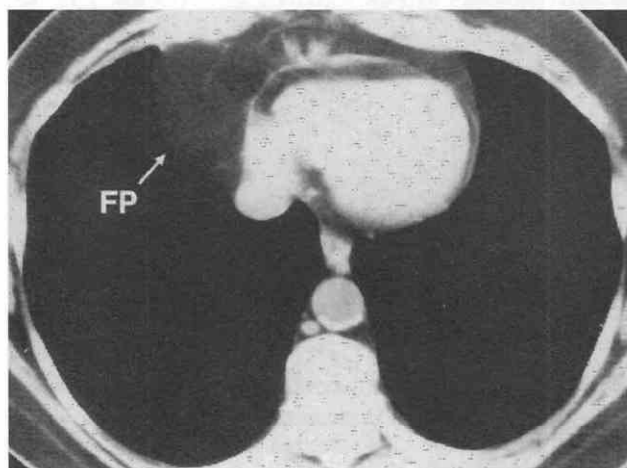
Cardiophrenic angle mass. CT shows that this mass is caused by a prominent epicardial fat pad (FP).
